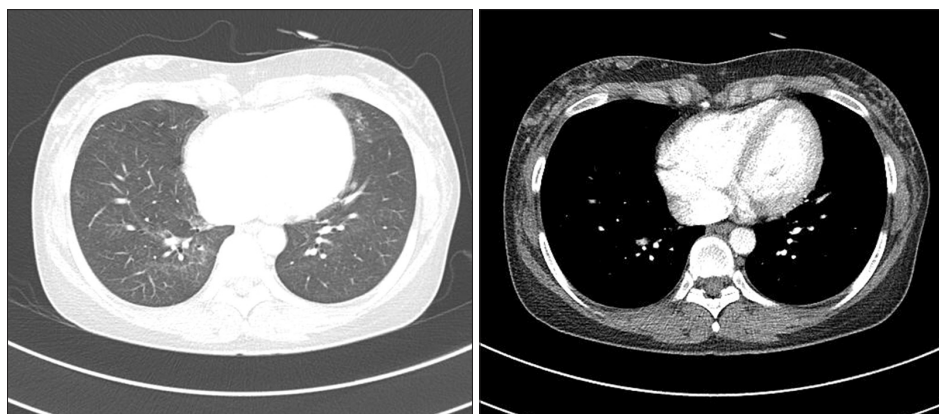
One month later, the contrast-enhanced chest computed tomography shows an improvement of multifocal ground glass opacity in both lungs and a decreased size of the right ventricle.
